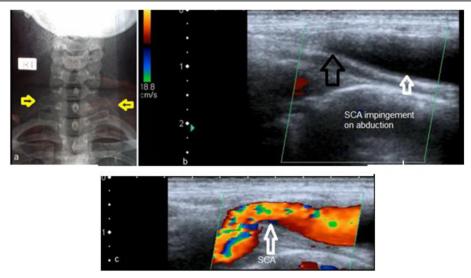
a Plain X-ray image (AP view) showing bilateral cervical ribs (transverse yellow arrows). b Color Doppler image showing the left subclavian artery being impinged by 180° of arm abduction with no detectable flow in the distal segment (open white arrow) and severe narrowing "peak configuration" of the compressed segment (open black arrow). c Color Doppler image for the same artery but with 120° of arm abduction showing less significant stenosis of the artery denoted by the color aliasing (open white arrow) with filling of the distal segment
